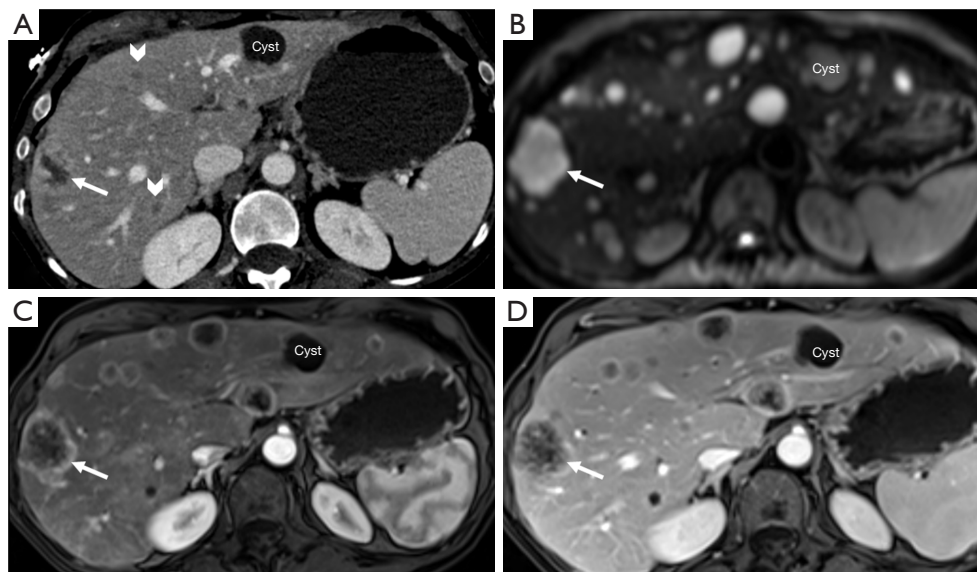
Liver metastases. Axial (A) venous CT, (B) DWI-MRI, (C) arterial, and (D) venous MRI images at the same level with CT and MRI obtained within 14 days of each other demonstrating numerous rim-enhancing, diffusion restricting liver metastases. Only one metastasis (arrow) and two indeterminate lesions (chevrons) are appreciated on this CT slice, while over twenty can be appreciated on the MRI slices (demonstrating the increased sensitivity of MRI). CT, computed tomography; DWI-MRI, diffusion-weighted imaging magnetic resonance imaging.
